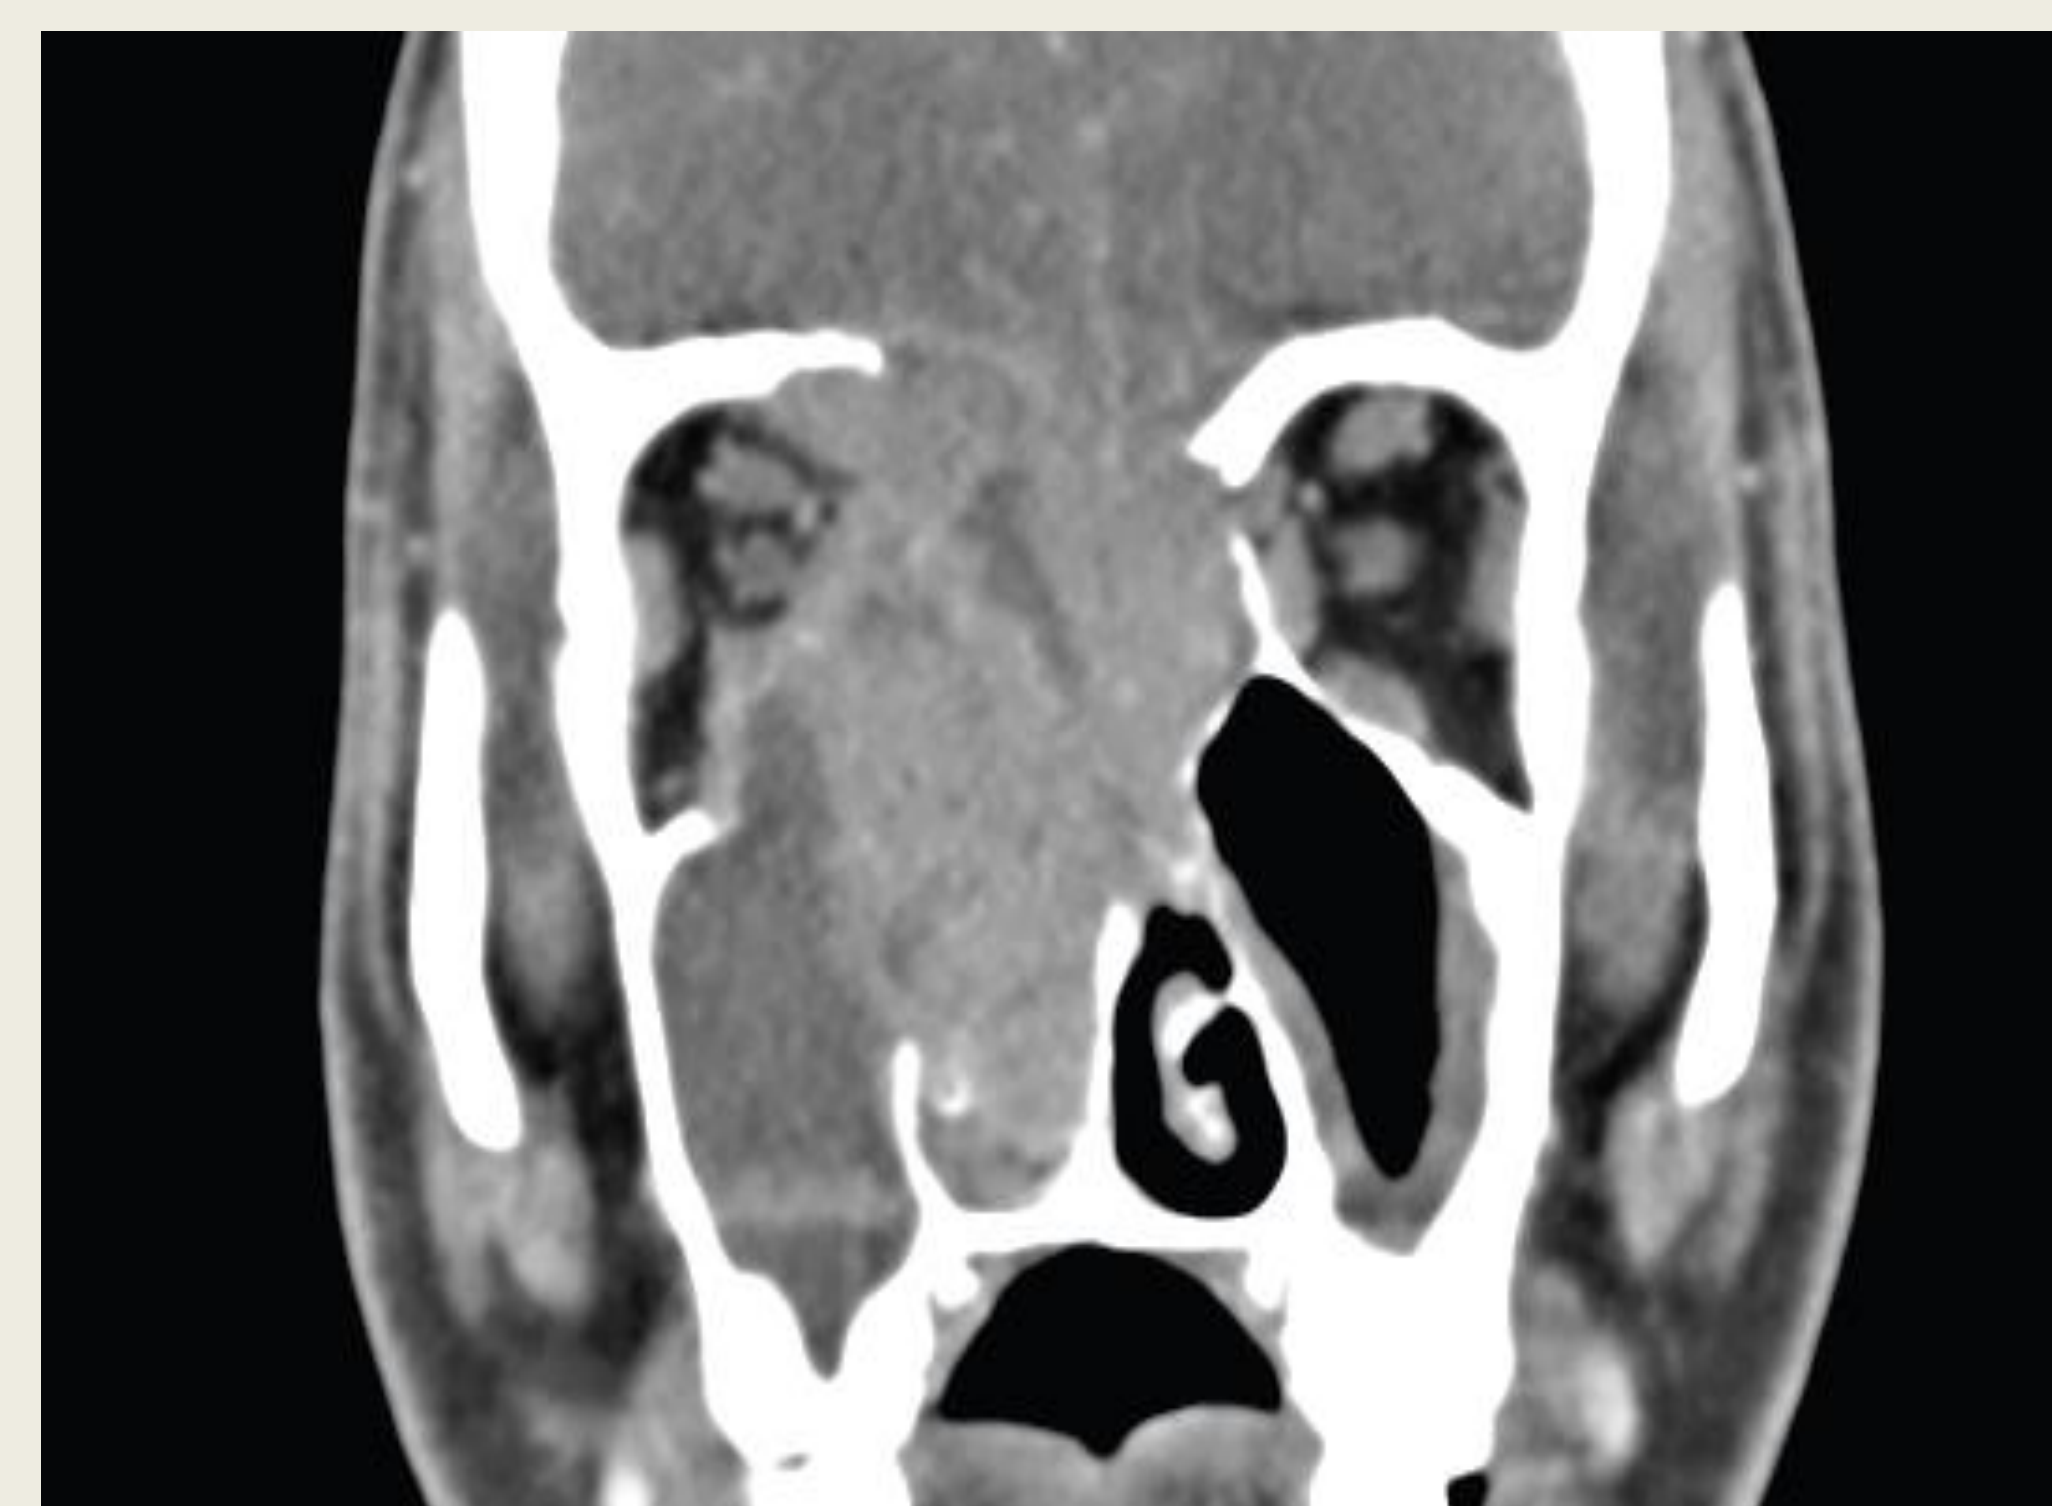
Coronal, contrasted CT through mid-orbit showing central and orbital extension (R>L)
